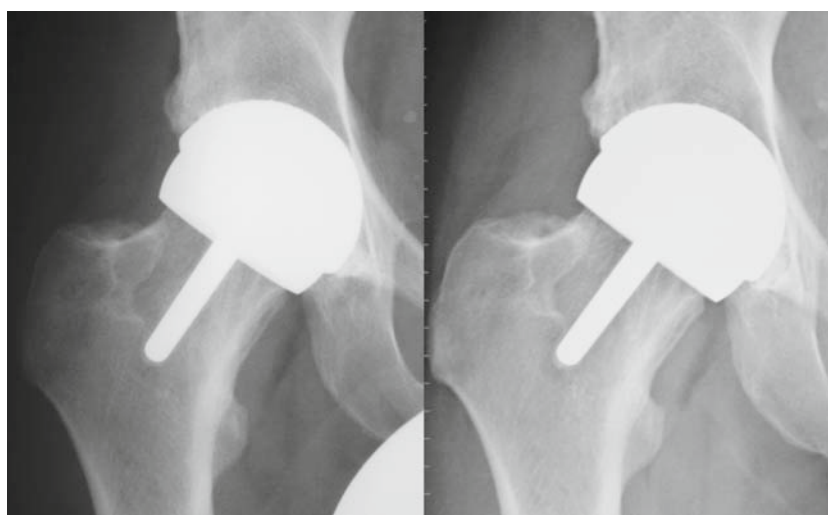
Five-year and 10-year postoperative radiographs of first BHR patient.
